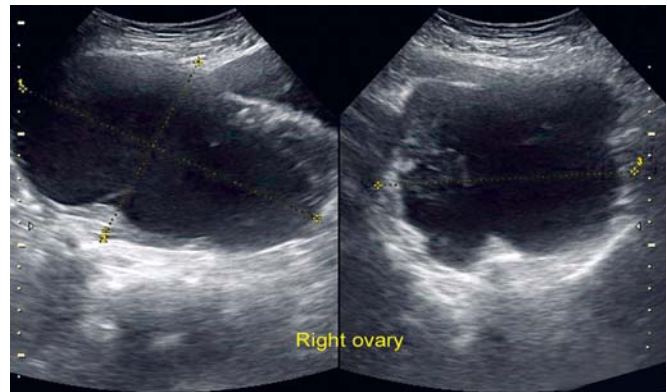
Shaggy lesions with echogenic fluid contents usually indicate old benign hemorrhagic lesions or mucinous neoplasm. The latter are often avascular and difficult to characterize. Magnetic resonance imaging is sensitive to iron content of lesions and helps to differentiate hemorrhagic lesions from those that do not contain blood
